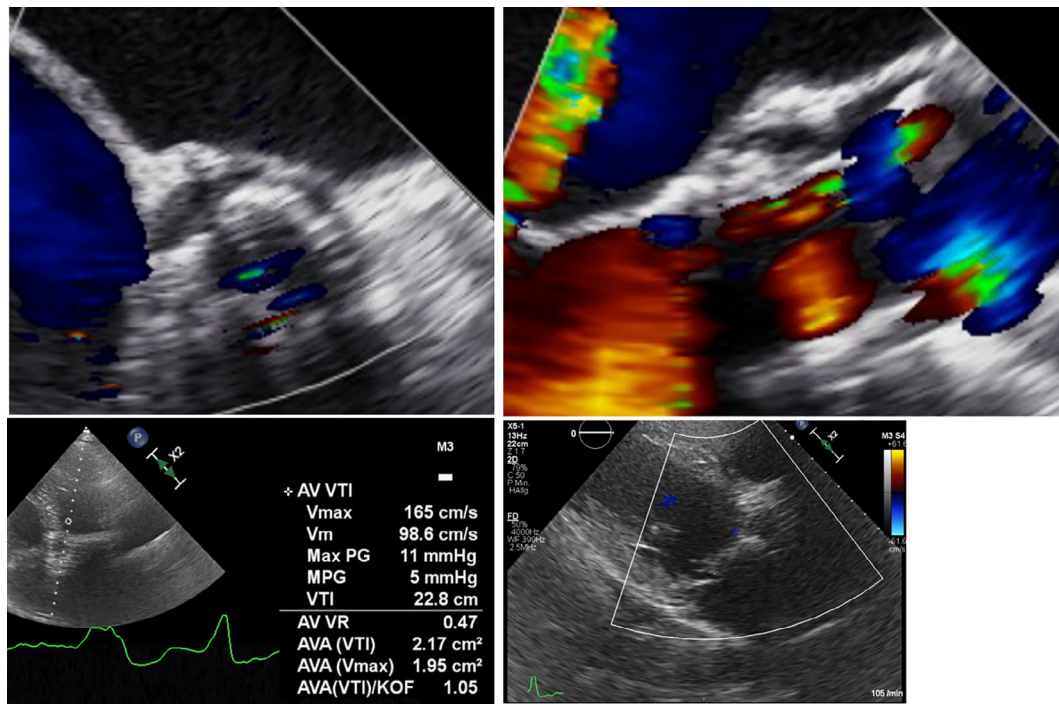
Intraoperative TEE merely showed trace PVL (a, b) after valve-in-valve-THV implantation. Transthoracic echocardiography measured 5 mmHg mean transprosthetic gradient without valvular or paravalvular regurgitation (c, d)
